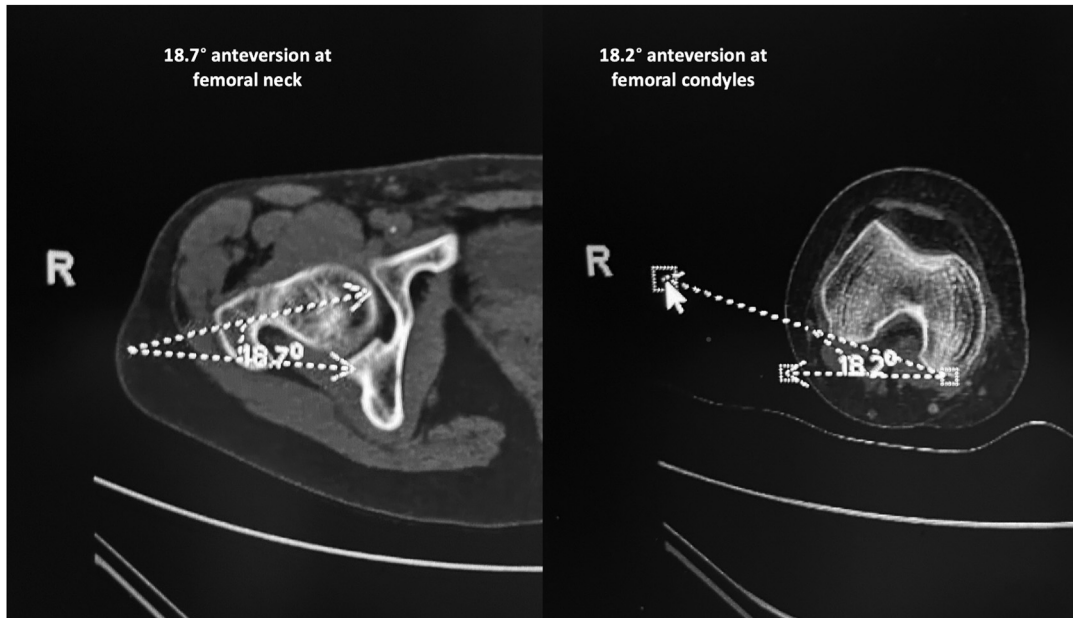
Preoperative computed tomography scanogram anteverision protocol used to assess femoral anteversion of femoral neck and distal femoral condyle. In this example, there is excessive combined femoral anteversion of approximately 37° (18.7° at the femoral neck and 18.2° at the femoral condyles). R indicates right side or R + right leg.
